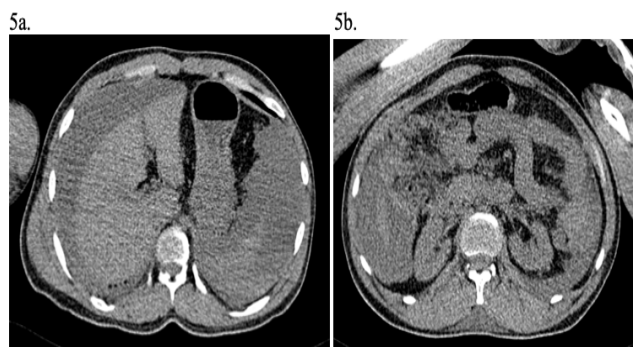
A fatal abdominal injury in a case fall from height that unable to be detected on CT. The autopsy revealed lacerated liver (a) with multiple hematoma at greater omentum, mesenteric, retroperitoneum and bilateral perinephric (b).
